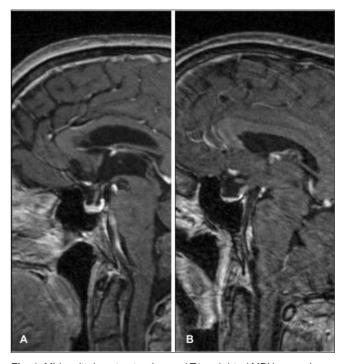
Midsagittal contrast-enhanced T1-weighted MRI image shows A) partial empty sella and B) total empty sella.
